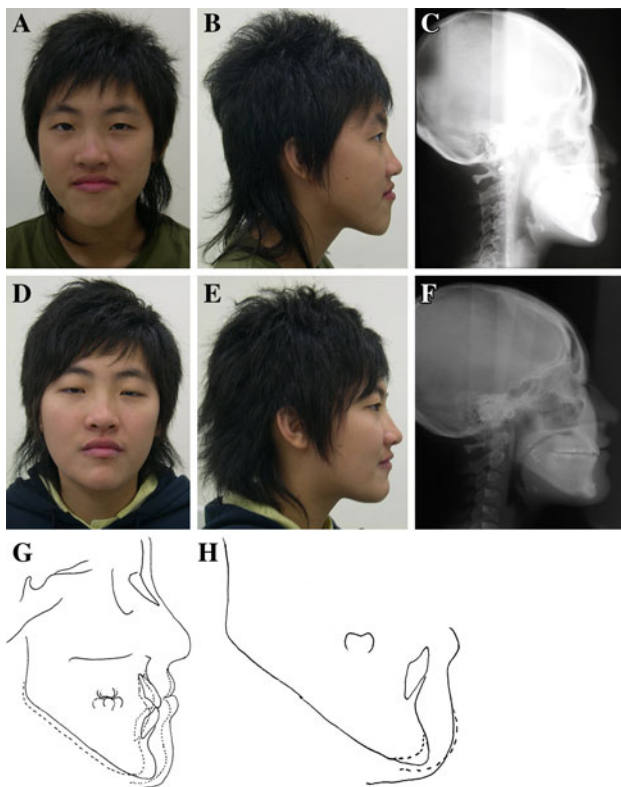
a–c Pretreatment view of a 20-year-old woman who underwent a mandibular setback and vertical chin reduction. d–f Post-treatment view when braces were detached. g–h Superimposition of cephalometric radiograph, registered on cranial base and best fit of mandibular anterior border, to show mandibular movement and genial movement
